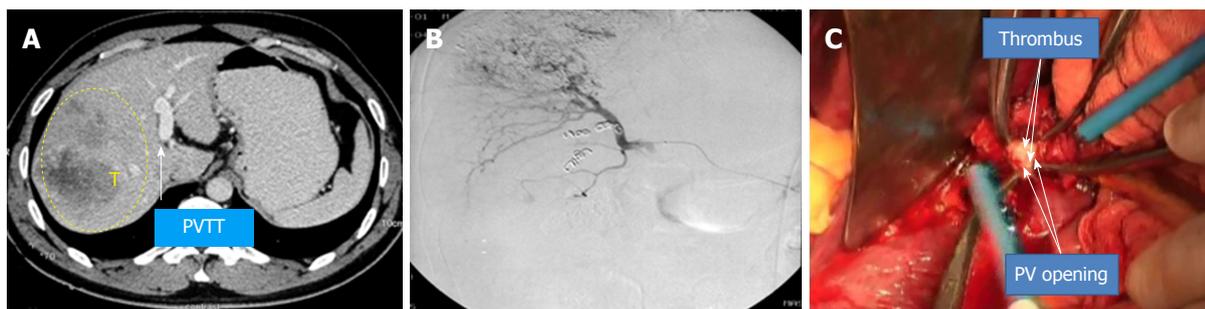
Case 1. A: The computed tomography scan showed tumor thrombus in the right portal vein. B: Transcatheter arterial chemoembolization was performed before the operation. C: The thrombus was extracted from the right portal vein opening. PV: Portal vein; PVTT: Portal vein tumor thrombus.
